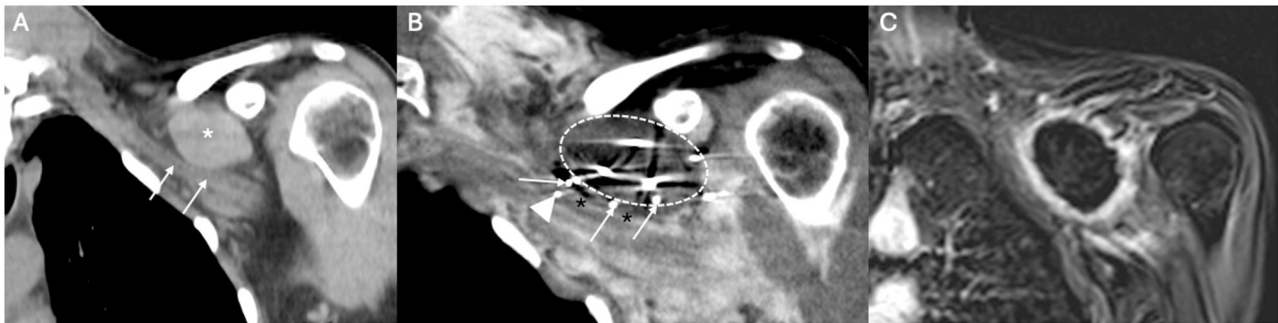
CA of an infraclavicular DF. Coronal CT scan (A) shows a DF (asterisk) located just above the brachial plexus (white arrows). To reduce the risk of nerve injury, hydrodissection and nerve stimulation were performed while freezing. Coronal CT scan (B) demonstrates the hypodense iceball (dotted circle), with 3 needles (white arrows) to perform hydrodissection which intervenes between the tumour and the brachial plexus (black asterisks). Freezing was performed with continuous injection of saline on all 3 needles and nerve stimulation (arrowhead). One-month follow-up contrast-enhanced MRI (C) shows devascularization of the tumour. Apart from partial axillary nerve palsy, the patient did not suffer from major neural injury. Abbreviations: CA = cryoablation; DF = desmoid fibromatosis.
